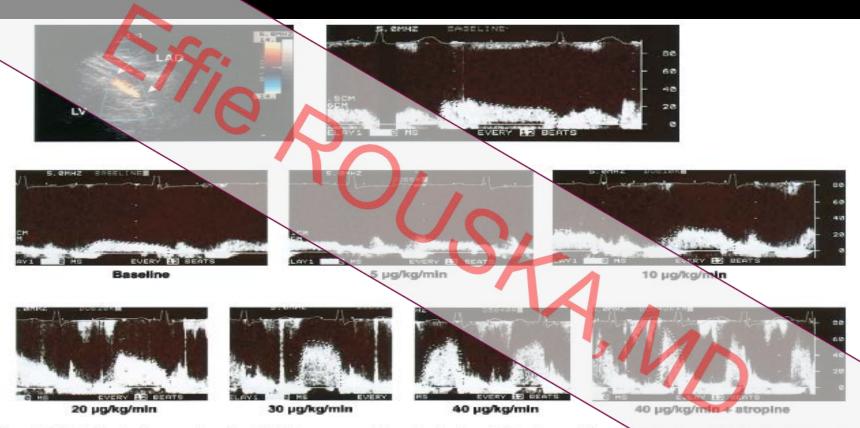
Color Doppler flow mapping of modified low parasternal long-axis view (top left) and spectral Doppler wating (top right) in distal left anterior descending coronary artery (LAD) after contrast enhancement. Color-coded blood flow in the LAD is clearly seen (arrow). Spectral Doppler shows biphasic coronary flow with predominance of diastolic component. Middle and lower panels show an example of another patient with normal response. After infusion of dobutamine, coronary flow velocity gradually increased. Baseline diastolic mean velocity was 17.2 cm/s, and flow socity increased to 54.4 cm/s after injection of atropine; thus, coronary flow velocity ratio peak is 3.16. Speed of recording 100 mm/s, velocity scale 80 cm/s LV = left ventricle.
